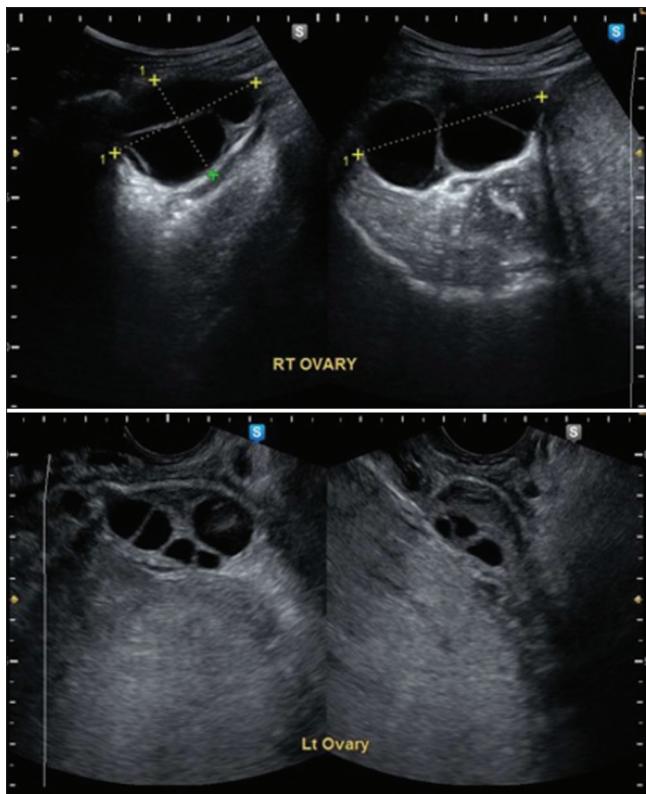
Bilateral theca lutein cysts in transvaginal ultrasound
